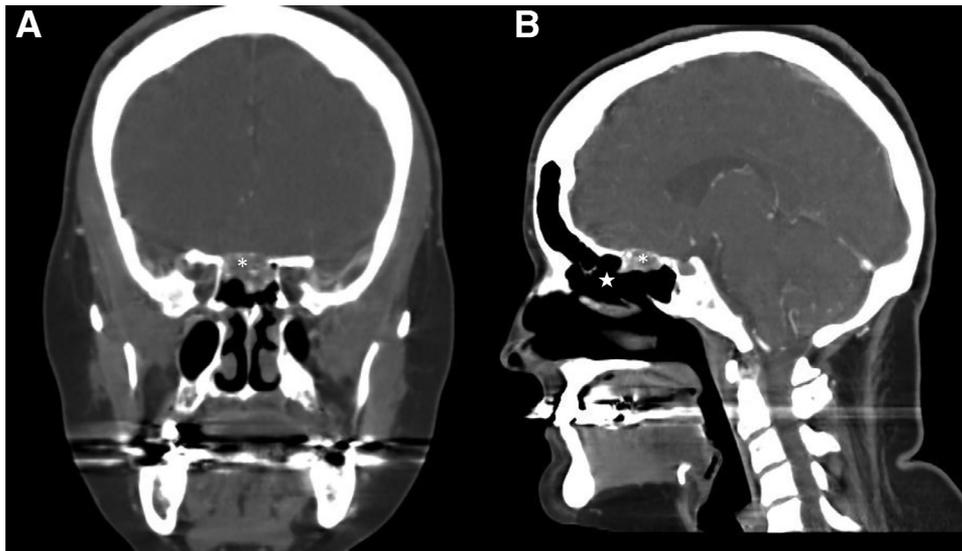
Recurrent ossifying fibroma at the planum sphenoidale. On coronal computed tomography (A) the recurrent disease is noted at the skull base (asterisk). On the sagittal view (B), the lesion is localized to the planum sphenoidale (asterisk). Extensive postoperative changes are also noted (star). Radiographic characteristic findings of OF as in [Figure 4](#) are not identified in this recurrent case. Images courtesy of Ricardo Carrau, MD.
